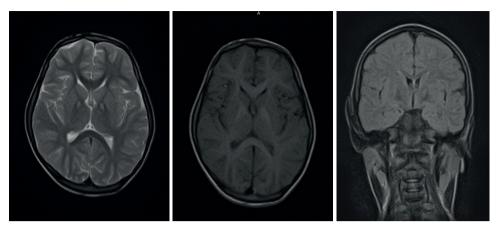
Eye-of-the-tiger sign visible on axial (first two) and coronal (last) planes of brain magnetic resonance imaging.
